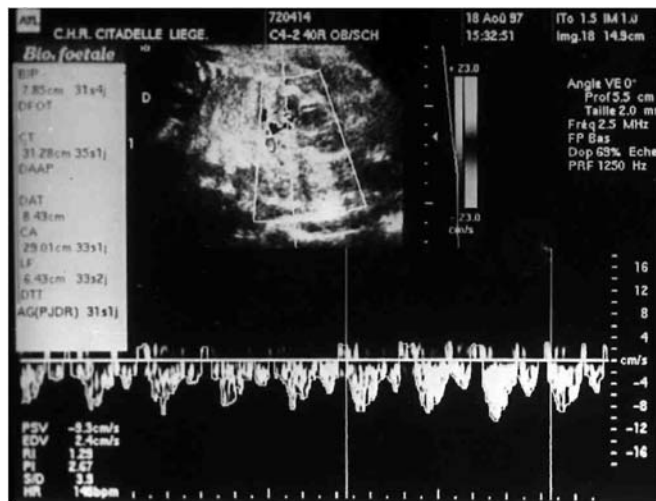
Flow-velocity waveforms with postsystolic incisura in the renal artery at 31st week of gestation. The Doppler gate is positioned over the main renal artery
